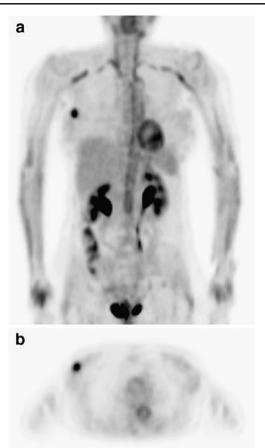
A 57-year-old female with fever of unknown origin. Maximum intensity projection (a) and transverse slice (b) show diffuse high FDG uptake in the aorta and large vessels as well as very intense focal uptake in a 4-mm large cancer in the right breast
